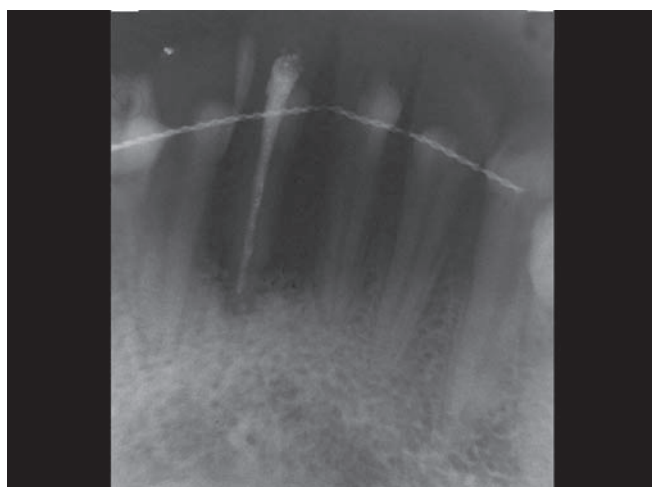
Postoperative radiograph after 6 months
